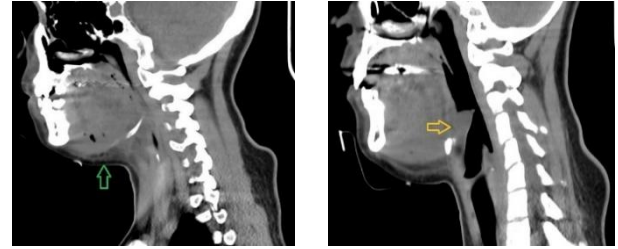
CT sagittal view
